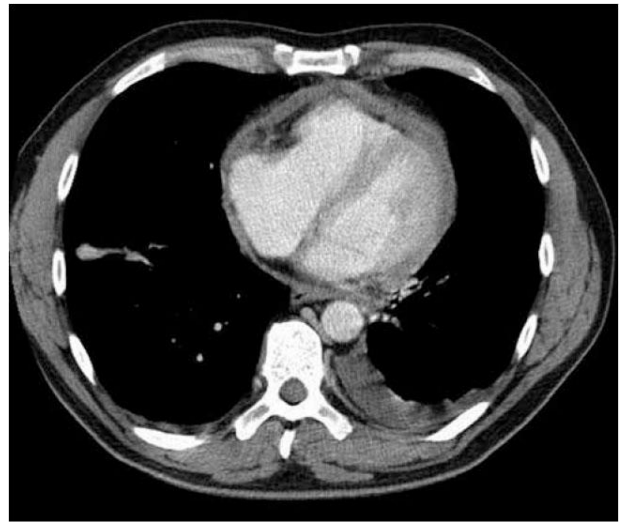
Chest CT scan. Description in the article.
